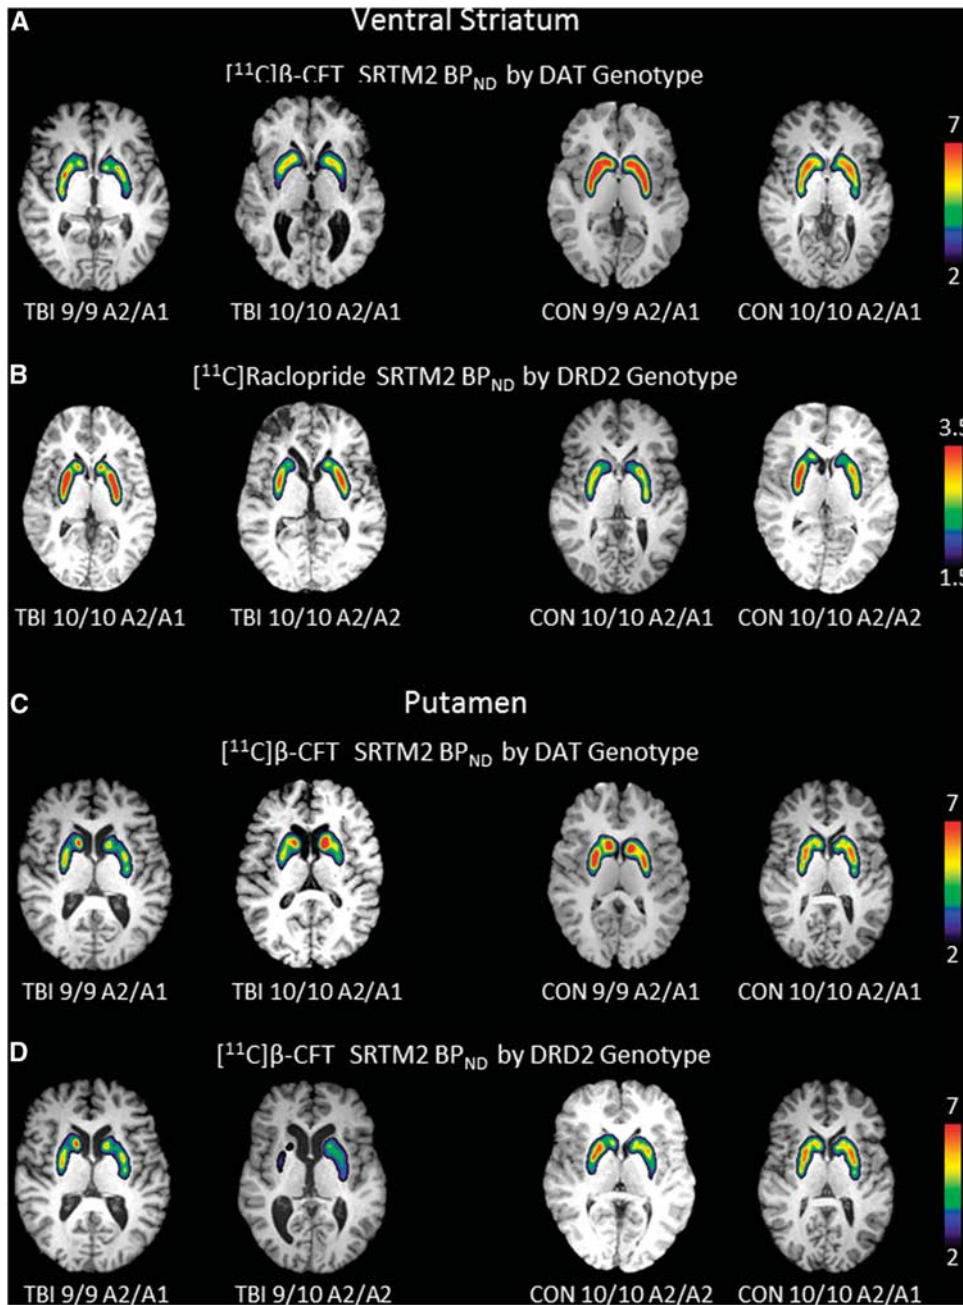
Images depict regional binding for [^{11}C] β -CFT and [^{11}C]raclopride based on SRTM2 analysis using cerebellum as reference region for a single slice through the ventral striatum (A/B) and putamen (C/D) in the axial plane overlaid onto high resolution anatomic MRI. (A) Shows a representative image of the ventral striatum and DAT binding in persons with DAT1 genotype 9/9 and DAT1 genotype 10/10 while keeping the DRD2 constant for the A2/A1 genotype in TBI (left two panels) and controls (right two panels). Panel B shows a representative image through the ventral striatum of DRD2 binding in persons with DRD2 genotype A2/A1 and DRD2 genotype A2/A2 while keeping DAT constant for the 10/10 genotype in TBI (left two panels) and controls (right two panels). Panel C shows a representative image of the putamen and DAT binding in persons with DAT1 genotype 9/9 and DAT1 genotype 10/10 while keeping the DRD2 constant for the A2/A1 genotype in TBI (left two panels) and controls (right two panels). Panel D shows a representative image of the putamen and DAT binding in persons with DRD2 genotype A1/A2 and A2/A2 while keeping the DAT1 genotype constant for the 10/10 genotype in TBI (left two panels) and controls (right two panels). Note: TBI 9/10 A2/A2 scale was 1.5 to 6. CON, control; DAT, dopamine transporter; MRI, magnetic resonance imaging; TBI, traumatic brain injury.
